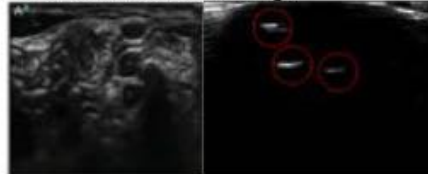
(Left). Interscalene brachial plexus on ultrasound [1].
